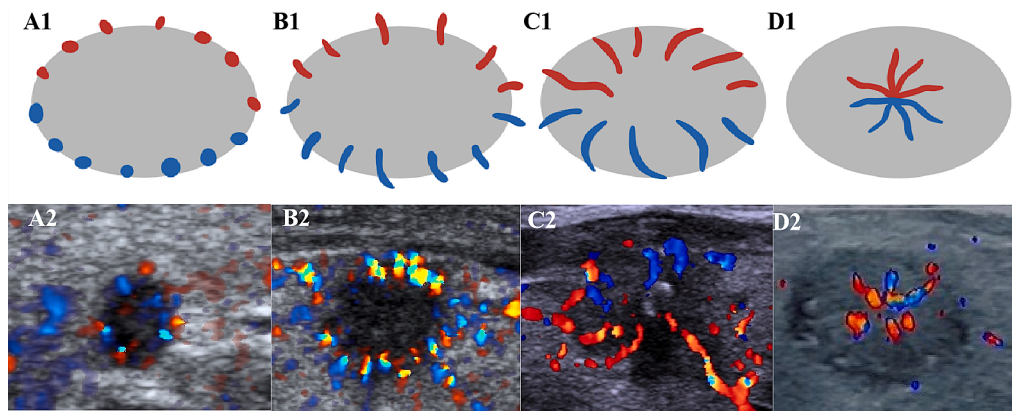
Examples of typical radiating blood flow signals A 1–2) it is represented as multiple color Doppler signals in the form of dots distributed radially around the nodule, and a large area without blood flow can be seen inside the nodule; B 1–2) it is represented as multiple color Doppler signals in the form of strips or short rods distributed radially around the nodule, and the color Doppler signals can cross the boundary of the nodule; a large area without blood flow can be seen inside the nodule; C 1–2) it is represented as multiple color Doppler signals in the form of strips or short rods distributed radially inside the nodule, and the color Doppler signals can cross the boundary of the nodule; there may be an area of no blood flow in the center; D 1–2) it is represented as multiple color Doppler signals in the form of strips or short rods distributed radially inside the nodule and generally does not extend past the boundary of the nodule.
